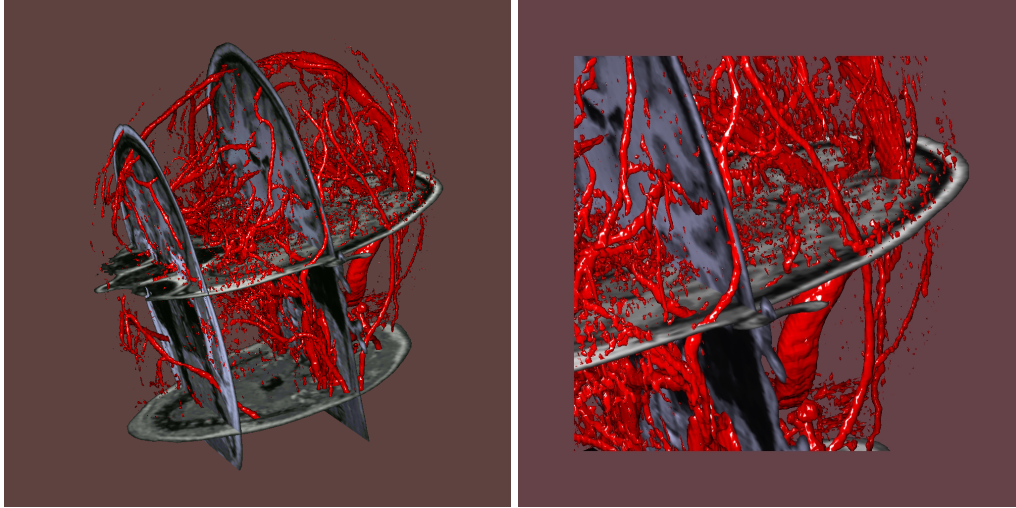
3D visualization of blood vessels within their anatomical context. Data were obtained from MRA (vessels) and MRI (cross-sectional images). (a): overview, rendered with 4 times oversampling of the original data. (b): detail, rendered with 8 times oversampling. The quality of visualization, especially of very small objects, is thus further improved.*
